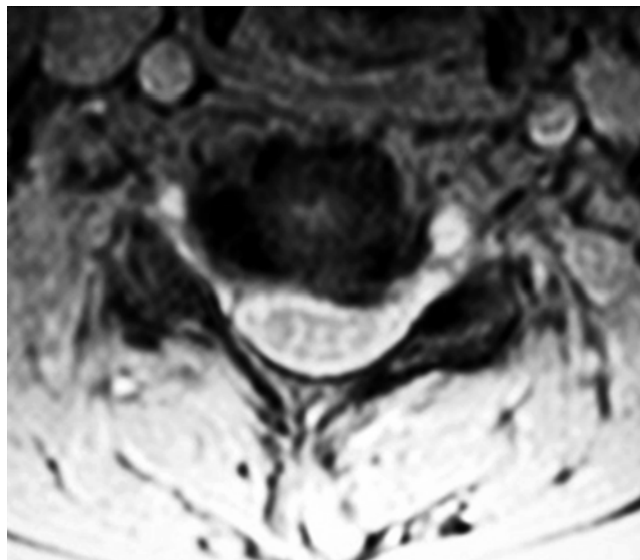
Preoperative axial MRI demonstrating severe neuroforaminal stenosis at cervical 5/6 and predominant right-sided radiculopathy
